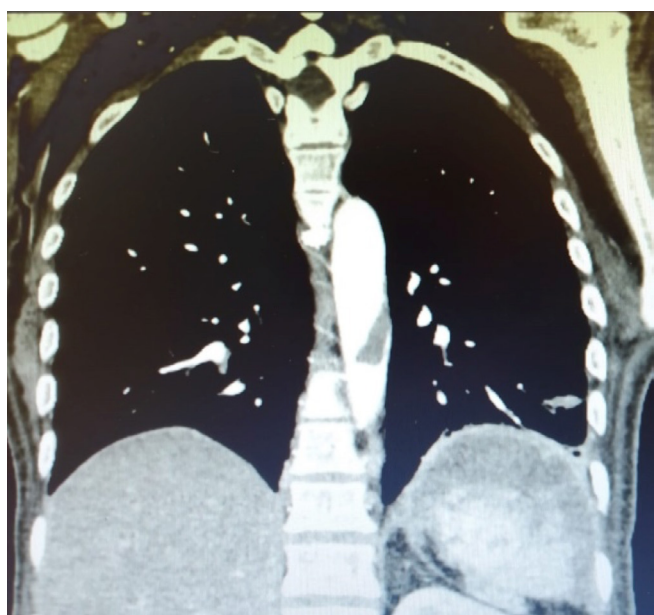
Abdominal CT angiography. Free-floating thrombus in the descending aorta in anterior-posterior projection.
